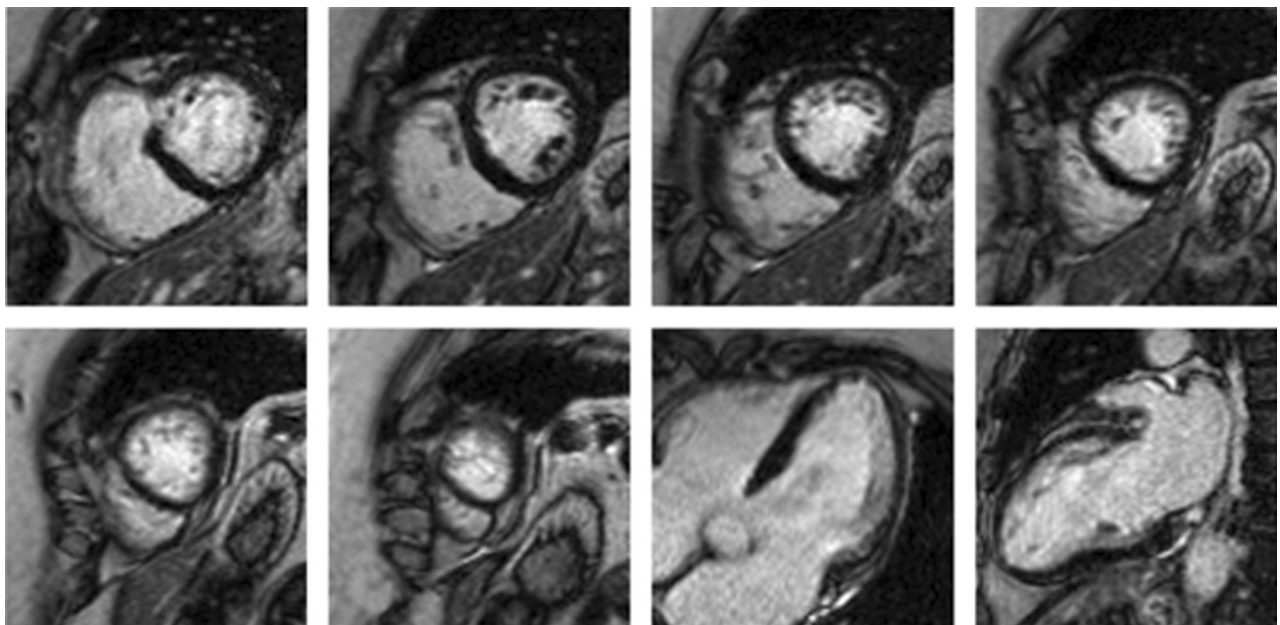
Cardiac MRI showed normal ventricular size and function without delayed enhancement; no stress inducible perfusion abnormalities.
